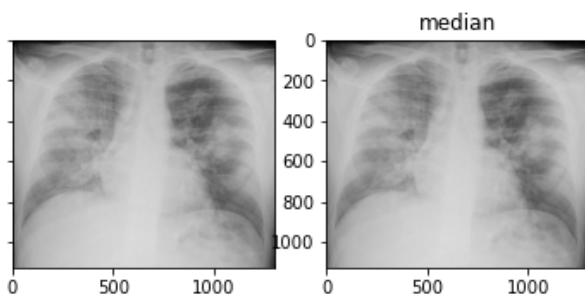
(b). Outputs of first X-Ray image before and after filtering it using Median Filter
